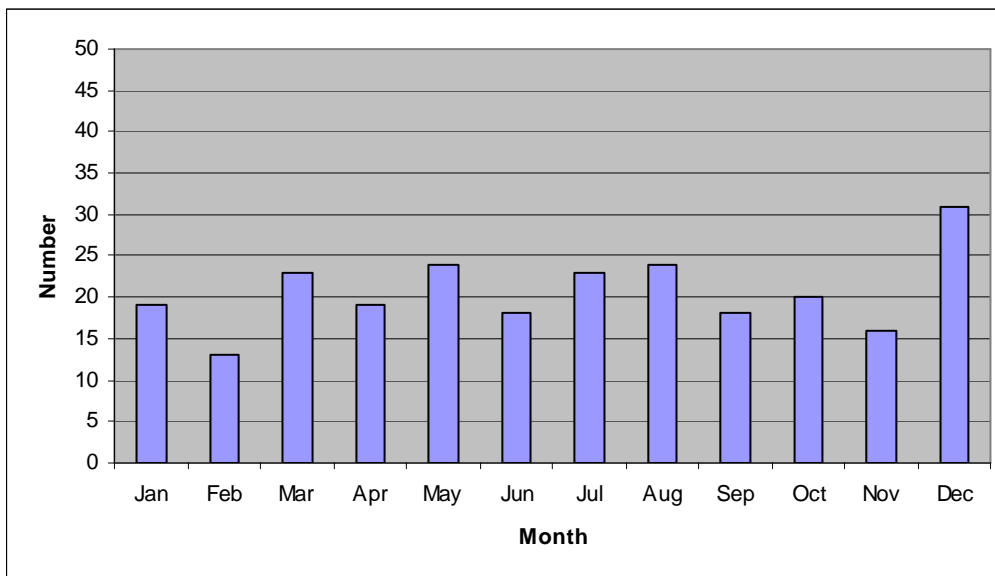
X-rays of skull, mandible and sinuses
